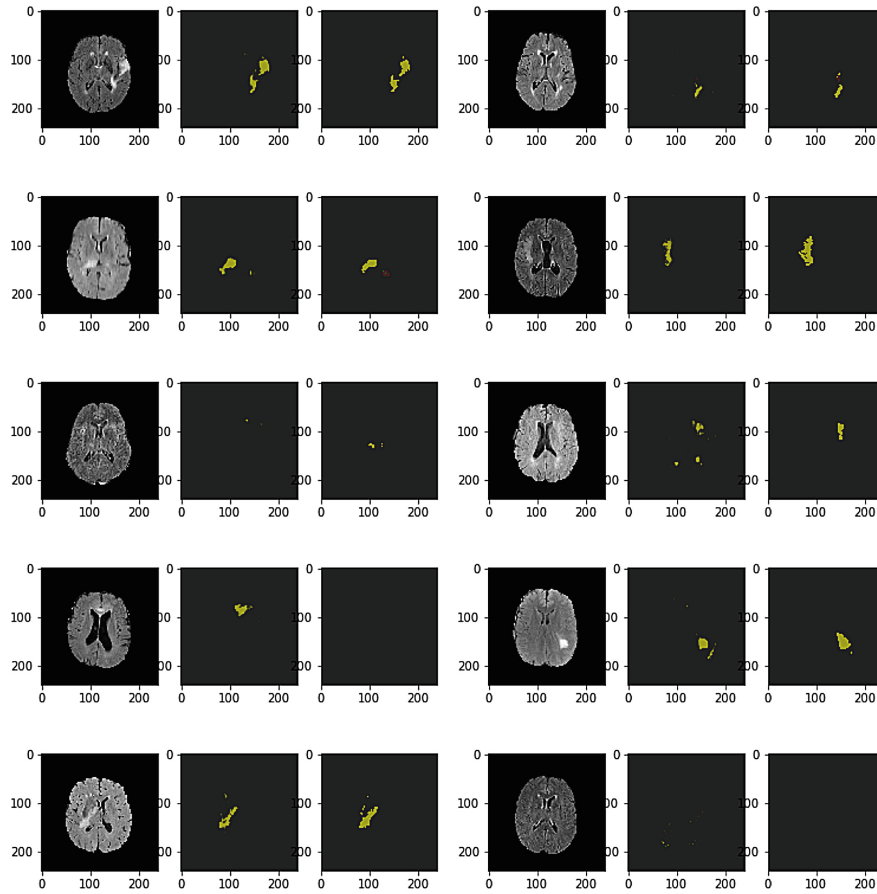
Visualization of 10 random cases with small size tumors and difficult cases. Some cases with small tumors and slices without tumor may be prone to false positives. Each case consists of visualizations of the image X (FLAIR), prediction labels Y_p , target labels Y_t . Green: Necrosis+Non-enhancing Tumor, Yellow: Edema, Red: Enhancing Tumor. (Color figure online)
